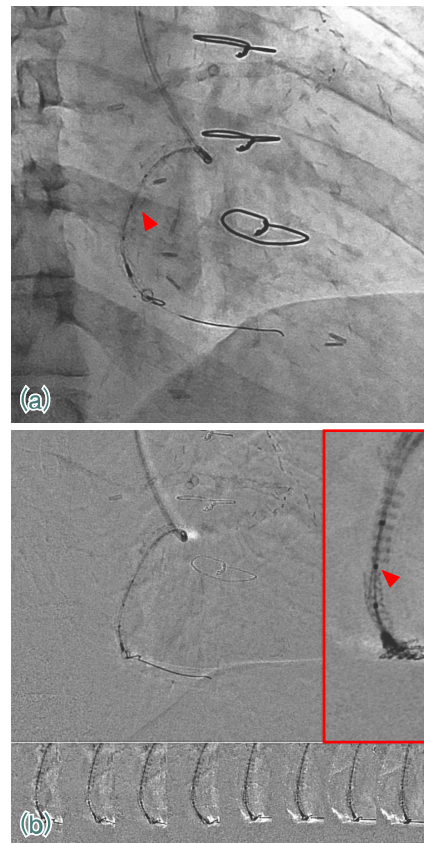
(a) Radiography image during IVUS. Difficult to gain a complete idea of the shape and location of the fracture
